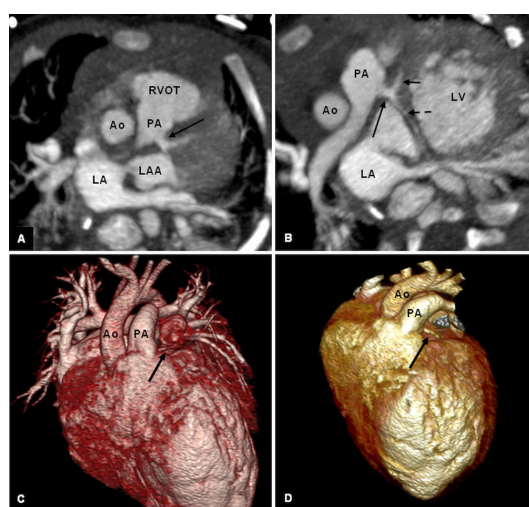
Anomalous left coronary artery from the pulmonary artery (PA) trunk/root junction on multidetector coronary CT angiography. (A) Origin of the left coronary artery (arrow) on the left aspect of PA. (B) The left coronary artery (long arrow) divides into two main arterial branches with course corresponding to the left anterior descending artery (short arrow) and the left circumflex artery (short dashed arrow). (C, D) Volumetric three-dimensional (3D) reconstructions depicting abnormal origin of the left coronary artery (arrow). Ao, aorta; LA, left atrium; LAA, left atrial appendage; LV, left ventricle; RVOT, right ventricular outflow tract.
